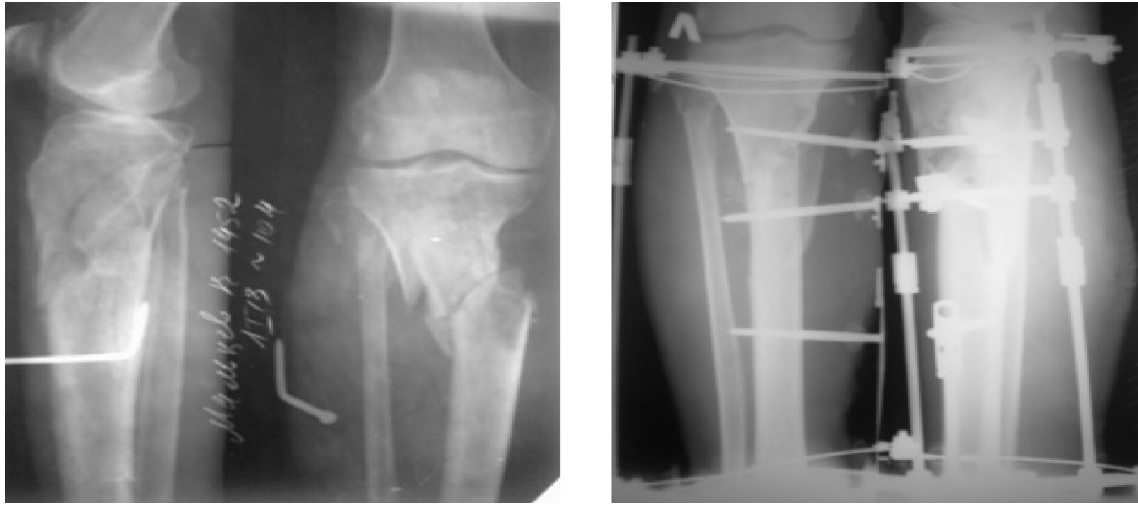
Radiographs of the patient before operation
